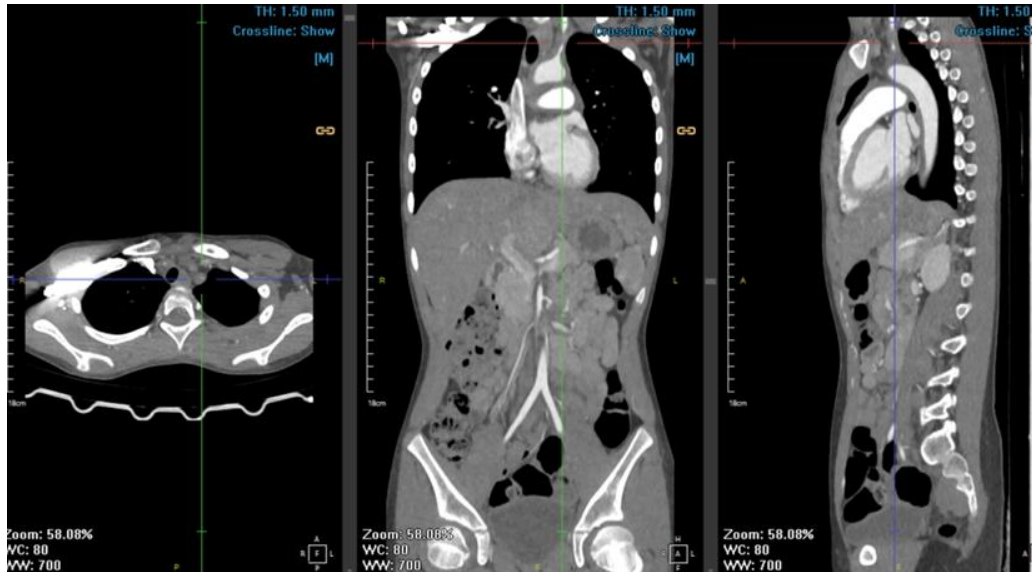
CT-scan Angiography Examination
